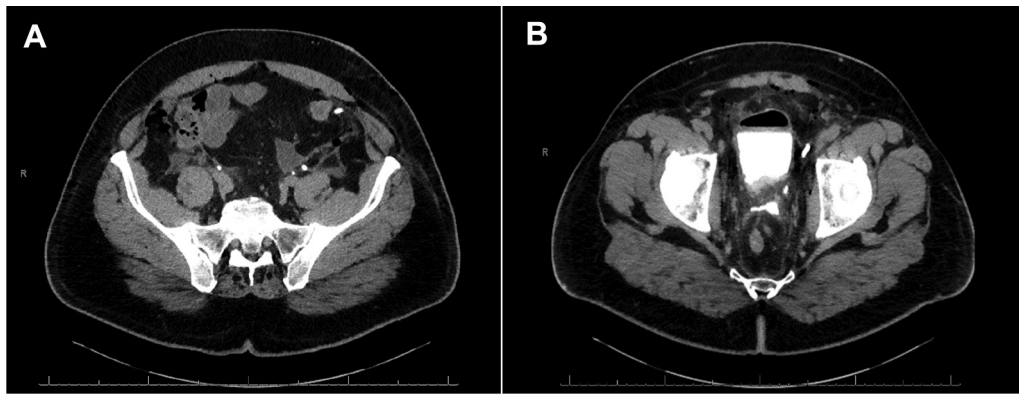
A) CT abdomen and pelvis 10 minute delayed axial image shows duplicated ureters on the patients left. B) CT abdomen and pelvis 10 minute delayed axial image shows contrast in the bladder as well as extravasation of contrast into the pelvis.
